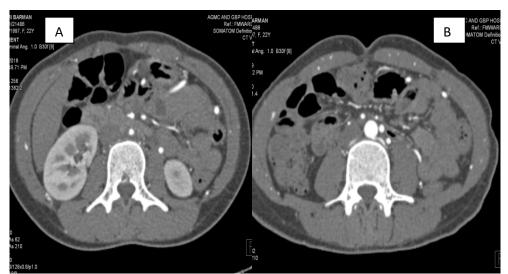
(Abdominal Angiography): CT angiography A & B show- narrowing of abdominal aorta with circumferential wall thickening
